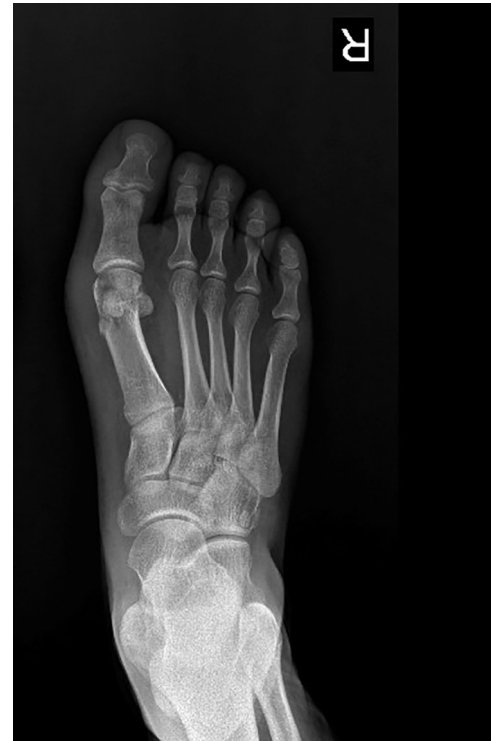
Postoperative radiographs of a chevron osteotomy with bioabsorbable pins used for fixation.
